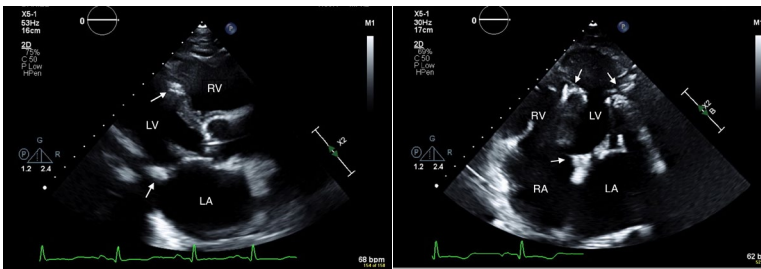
The parasternal view (left) and 4-chamber view of echocardiogram (right) showed calcification of mitral annulus, LV septum, and free wall (indicated by white arrows). [LA = left atrium; LV = left ventricle; RA = right atrium; LV = left ventricle.]
